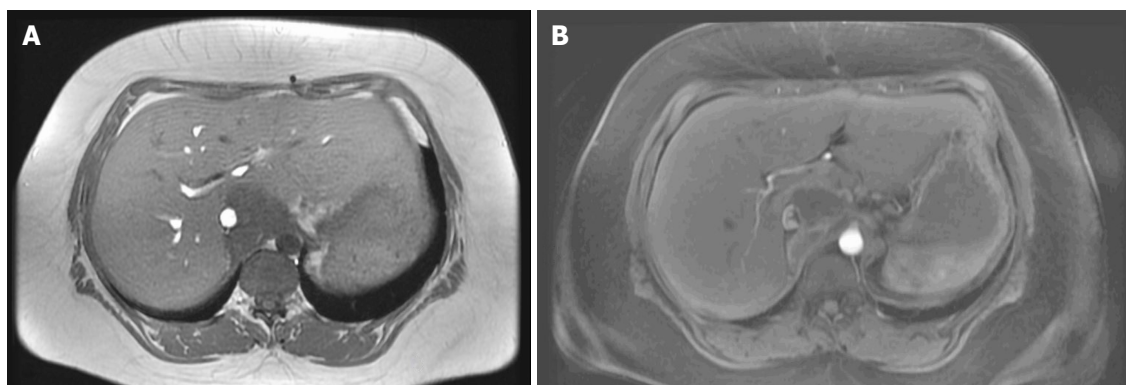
Magnetic resonance imaging shows an isolated liver metastasis in caudate lobe of the liver.
